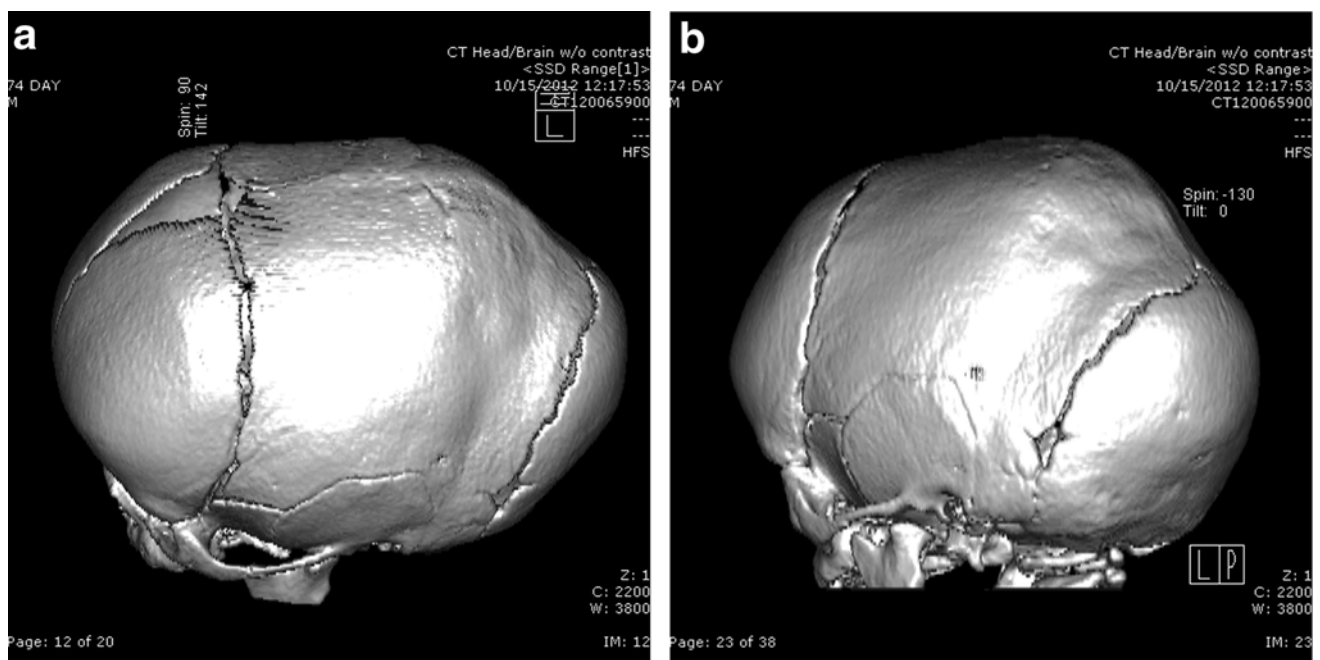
(a, b) CT scan of a 2-month-old infant with sagittal synostosis preoperatively
